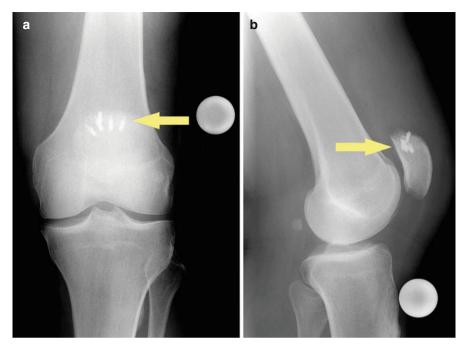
Anteroposterior (a) and lateral (b) radiographs of a left knee showing a repaired quadriceps tendon tear with suture anchors (*yellow arrows*) in the proximal pole of the patella
